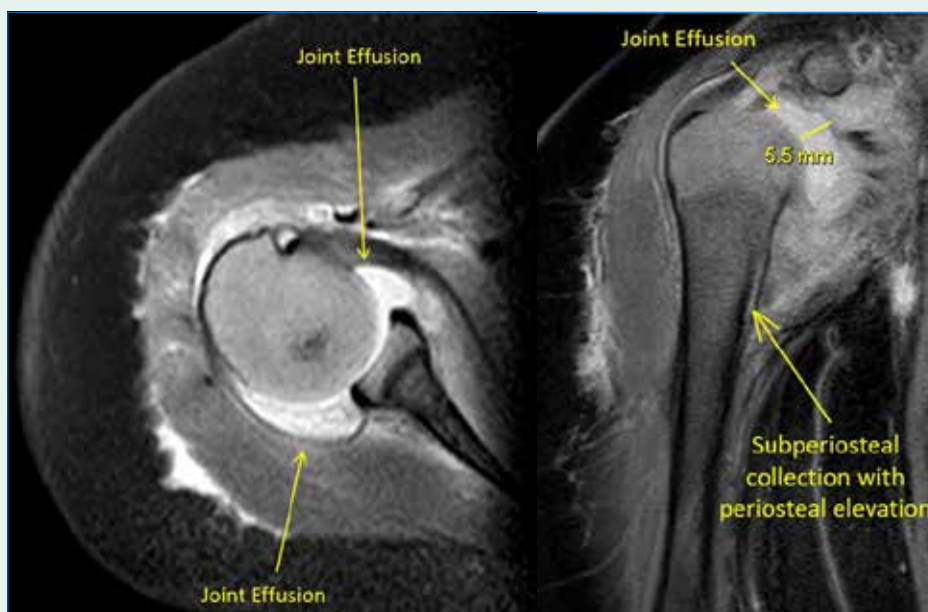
Annotated coronal and axial MRI sections of the right shoulder. This shows a joint effusion and subperiosteal collection of fluid tracking down the proximal humeral diaphysis anteromedially measuring up to 2mm in depth.
